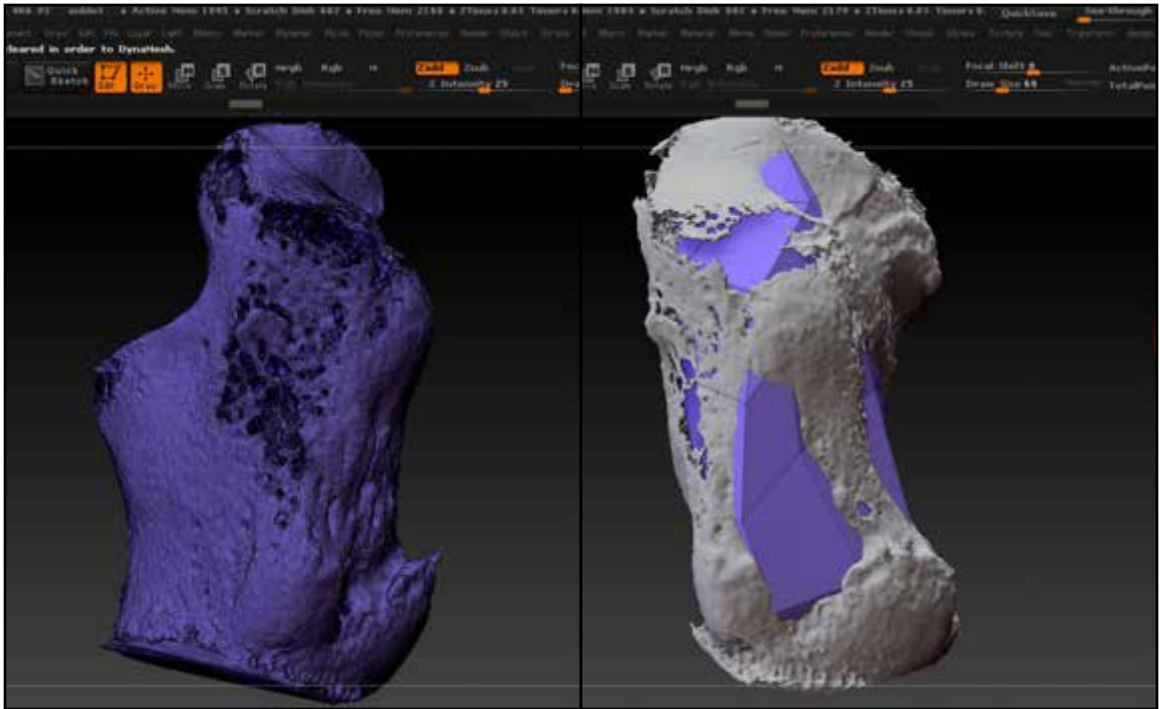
Suboptimal CT surface render calcaneus mesh with complex inner branched geometry. Figure 36. Low resolution Dynameshed duplicate mesh.
